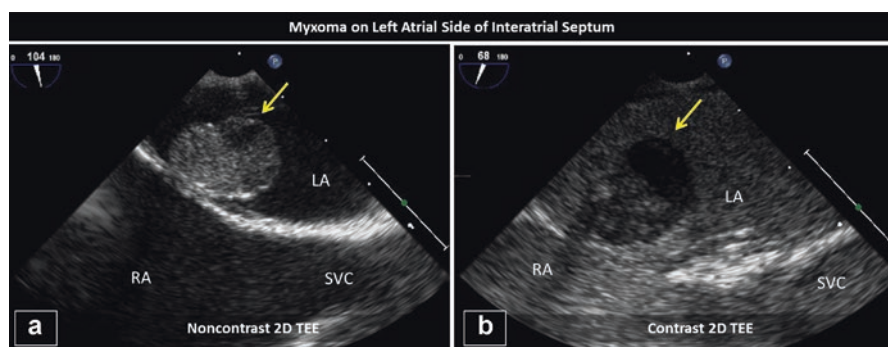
Myxoma. (a) Left atrial myxoma adherence to the interatrial septum visualized on TTE. (b) Echocardiographic contrast demonstrating partial opacification of left atrial myxoma. TEE Transesophageal echocardiogram, LA Left atrium, RA Right atrium, SVC Superior vena cava
